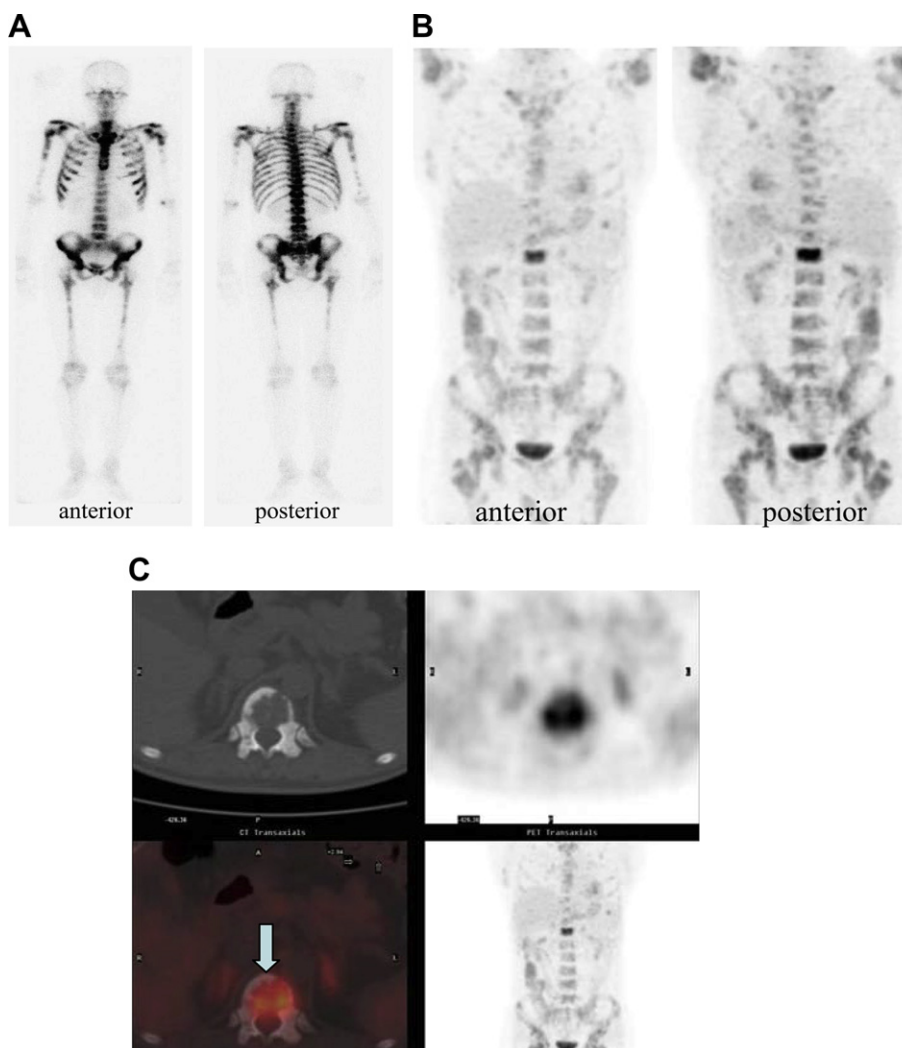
(A) In the patient diagnosed with gastric cancer, technetium-99m methyldiphosphonate bone scan revealed super bone scan pattern with absent renal radioactivity and diffusely mild heterogeneous skeletal radioactivity throughout the whole axial skeleton, ribs, head of clavicle, sternum, scapulae, proximal humeri and femora. (B) The ^{18}F -FDG PET scan showed extensively incremental ^{18}F -FDG avid bone marrow metabolism with SUVmax 3 in the axial skeleton (significantly in ileum and sacrum) and proximal humeri and femora. (C) Focally high grade of ^{18}F -FDG avidity (SUVmax 9) was noted in T12. PET/computed tomography fusion imaging identified a space occupied by a consistently high grade of ^{18}F -FDG avid hypodense tumor associated with peripheral osteolysis (arrow). ^{18}F -FDG PET = 18-fluorodeoxyglucose positron emission tomography; SUVmax = maximal standard uptake value.
